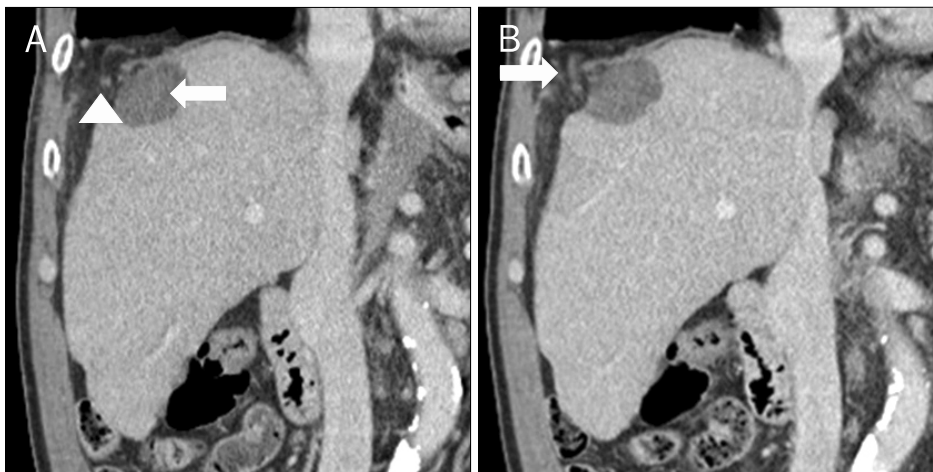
Abdomen CT findings. (A) Coronal abdomen CT revealed about a 2.0 cm sized defect (arrowhead) of the diaphragm adjacent to the lesion (arrow) that was ablated. (B) Coronal abdomen CT showed herniation of mesenteric fat and blood vessels (arrow).
